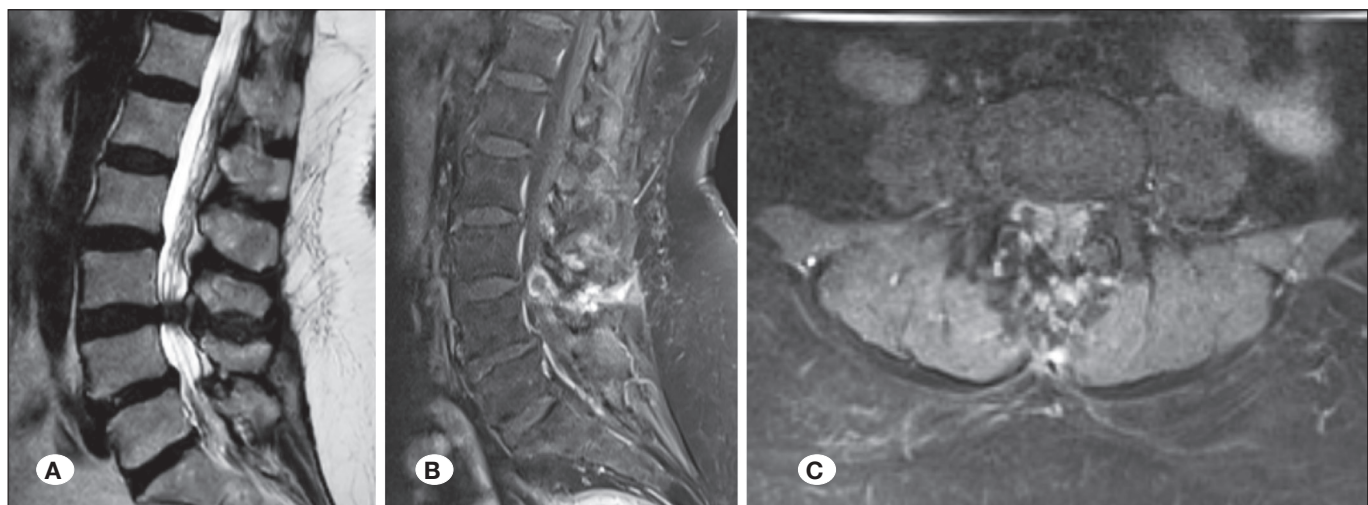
Preoperative T2W and gadolinium-enhanced T1W MR images show lumbar stenosis at the L3-4 level with contrast enhancement on the right side of the posterior wall of the spinal canal (A, B, C).
